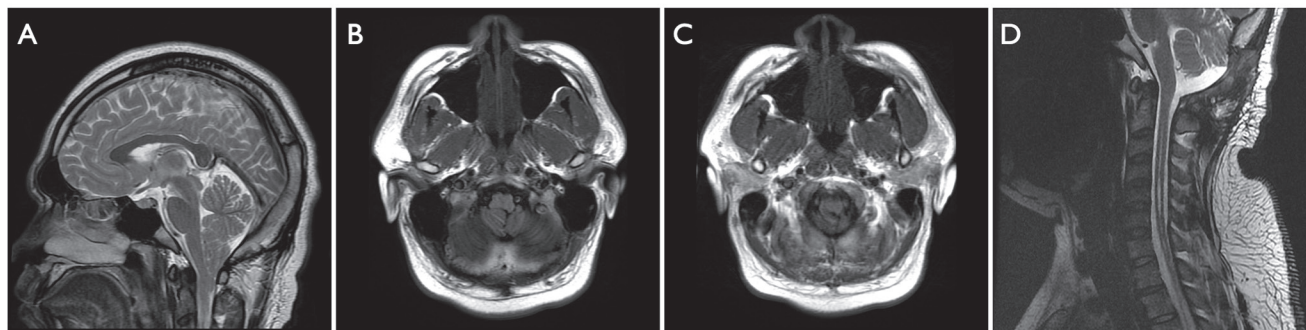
Magnetic resonance imaging of the brain revealed a 25-mm caudal descent of the cerebellar tonsils (A, T2-weighted image, sagittal view) with compression mainly to the right posterolateral aspect of the lower brain stem and upper cervical spinal cord (B, C, T1-weighted images, axial view). Postoperative magnetic resonance imaging showed release of the compression (D, T2-weighted image, sagittal view).
